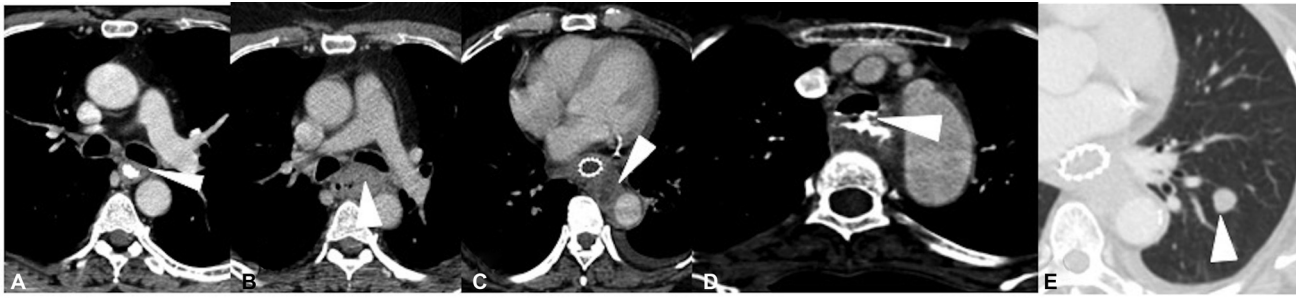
Esophageal carcinoma staging on axial contrast-enhanced computed tomography. (A) Mild asymmetric mid-esophageal wall thickening (arrowhead), with no peri-adventitial infiltration and maintained fat planes with the adjacent structures (T2). (B) Mid-esophageal growth with periadventitial fat infiltration (T3) without any tracheobronchial or aortic invasion. The mass is seen to indent upon posterior wall of left mainstem bronchus (arrowhead); however, invasion was ruled out by bronchoscopy. (C) More than 90-degree arc of contact between the esophageal mass and aorta with involvement of aortic wall (arrowhead), along with soft tissue extension into the triangular fat pad indicating aortic invasion (T4b). (D) Irregular circumferential thickening involving the upper thoracic esophagus with frank fistulous communication with the tracheal lumen (arrowhead), and passage of oral positive contrast into the trachea (T4b). (E) Well defined left lower lobe nodule (arrowhead) on lung window, in a case of esophageal cancer, suggestive of lung metastasis (M1).
